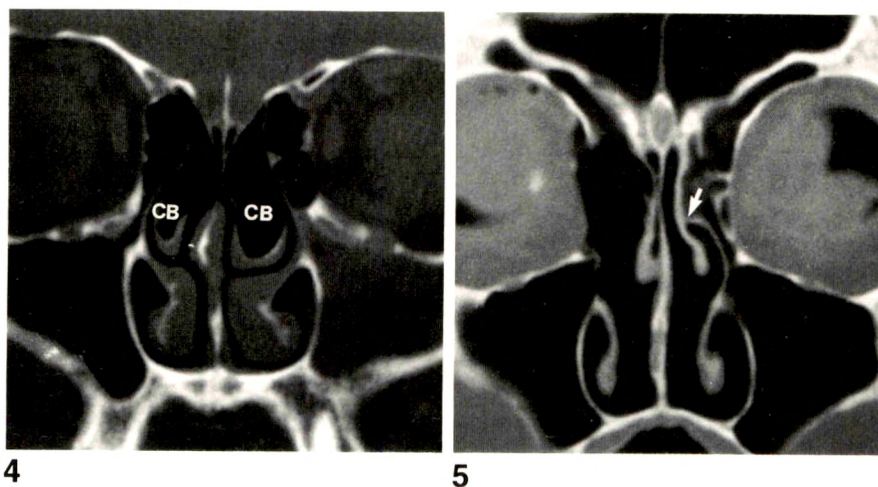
CT scan shows bilateral concha bullosa (CB). Note narrowing of left middle meatus and infundibulum and associated thickening of left maxillary mucosal lining.
